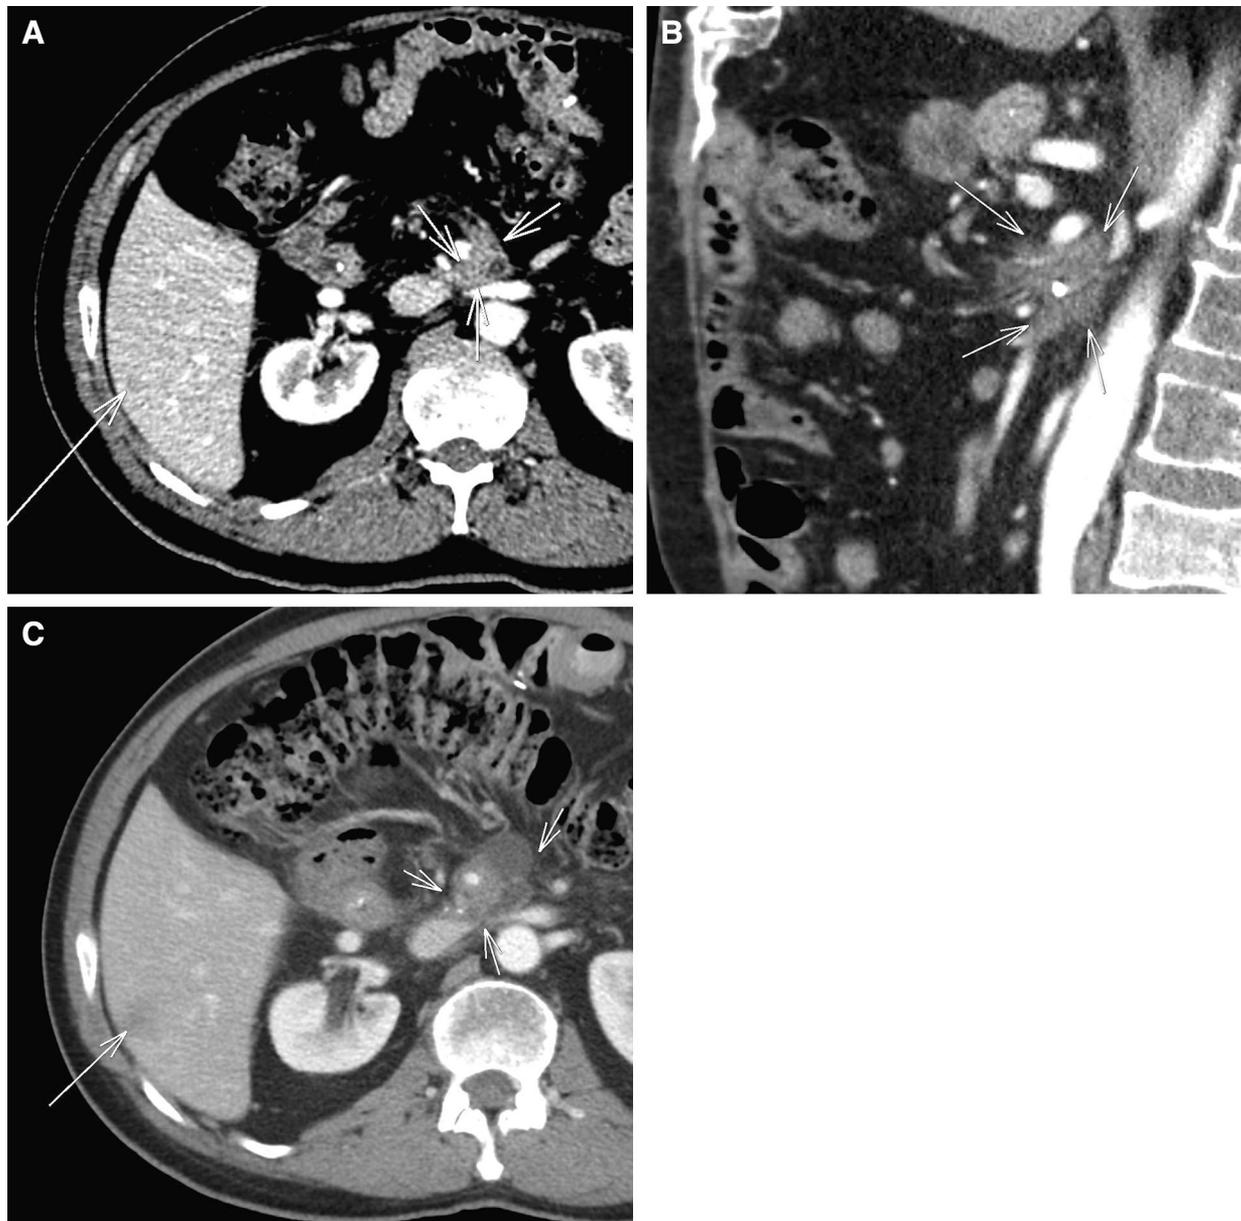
A Axial venous phase CT on a liver window and B sagittal venous phase CT on soft tissue window from a CT in a 46-year-old male with recurrent pancreatic cancer. Initial interpretation did not describe any liver lesions and stated “soft tissue associated with surgical clips possibly representing residual tissue of the uncinata process.” Second-opinion interpretation stated, “soft tissue mass between the superior mesenteric artery, superior mesenteric
